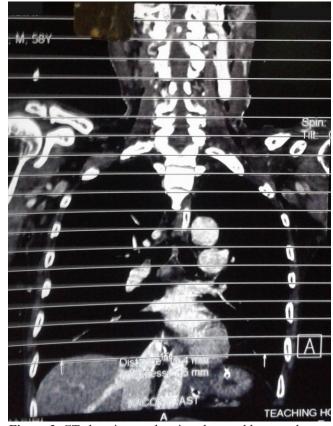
CT chest image showing shattered laryngeal
